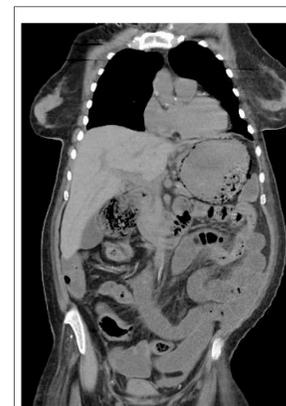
Coronal images from CT Chest/Abdomen/Pelvis from admission demonstrating portal venous gas, intramural gas, and severe gastric distention.
